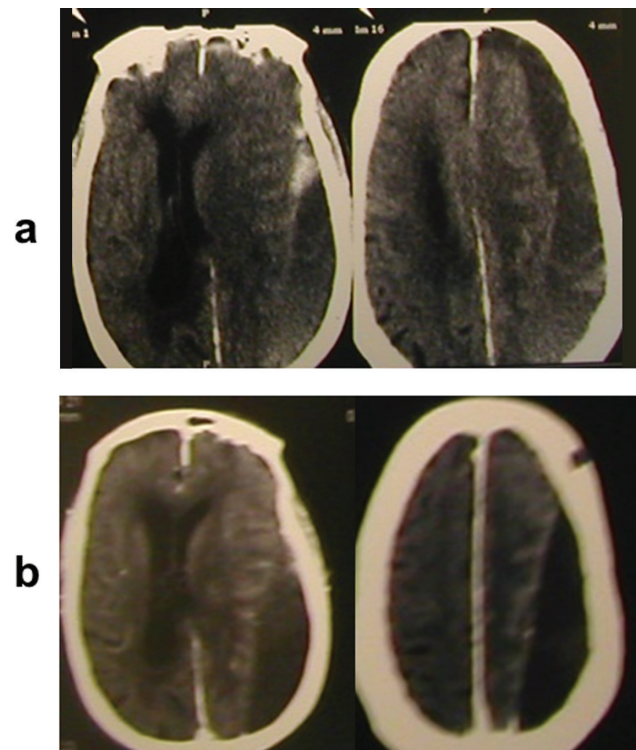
An 87-year-old man was operated for (a) a left-sided layered CSDH of mixed density. He made initial brisk clinical recovery, then relapsed. (b) Repeat cranial CT on POD 13 showed the resolution of the frontal component of the initial lesion but a persistence of the parieto-occipital component.
